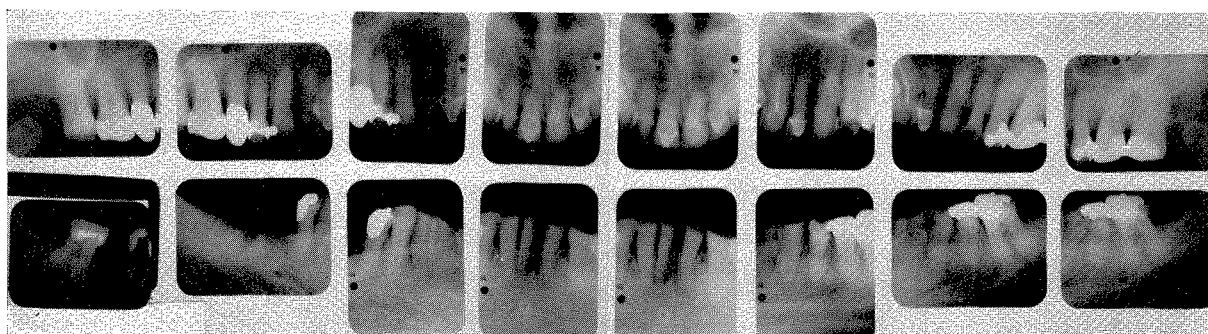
Roentgenograms taken in September, 1953, before any work was undertaken. The lower right molar film was inserted although this tooth had been removed in July, 1953, as the bicuspid film indicates. (Read text.)
